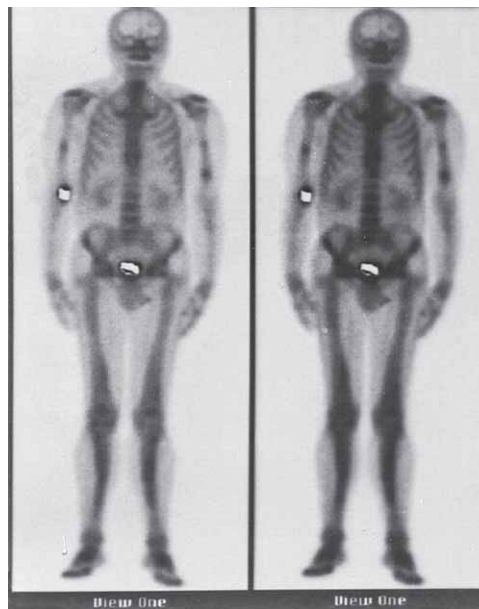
Father's bone scintigraphy.
